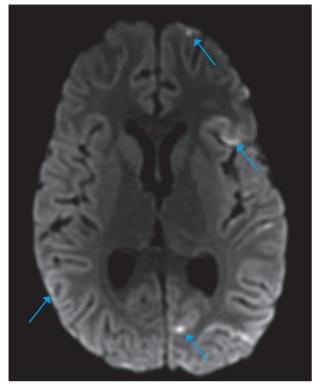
Brain magnetic resonance. Axial DWI. Millimetric cortical lesions with restricted diffusion in both cerebral hemispheres and left cerebellum.
